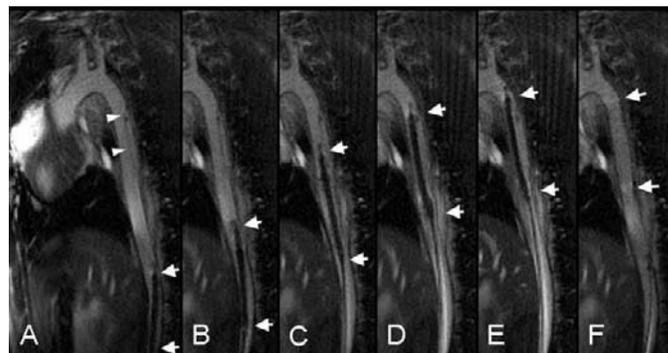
Advancement of the stent-graft delivery system (arrows) up to the level of the dissection (arrowheads) under real-time MRI guidance. Real-time PR TrueFISP imaging provided 7 fps.
